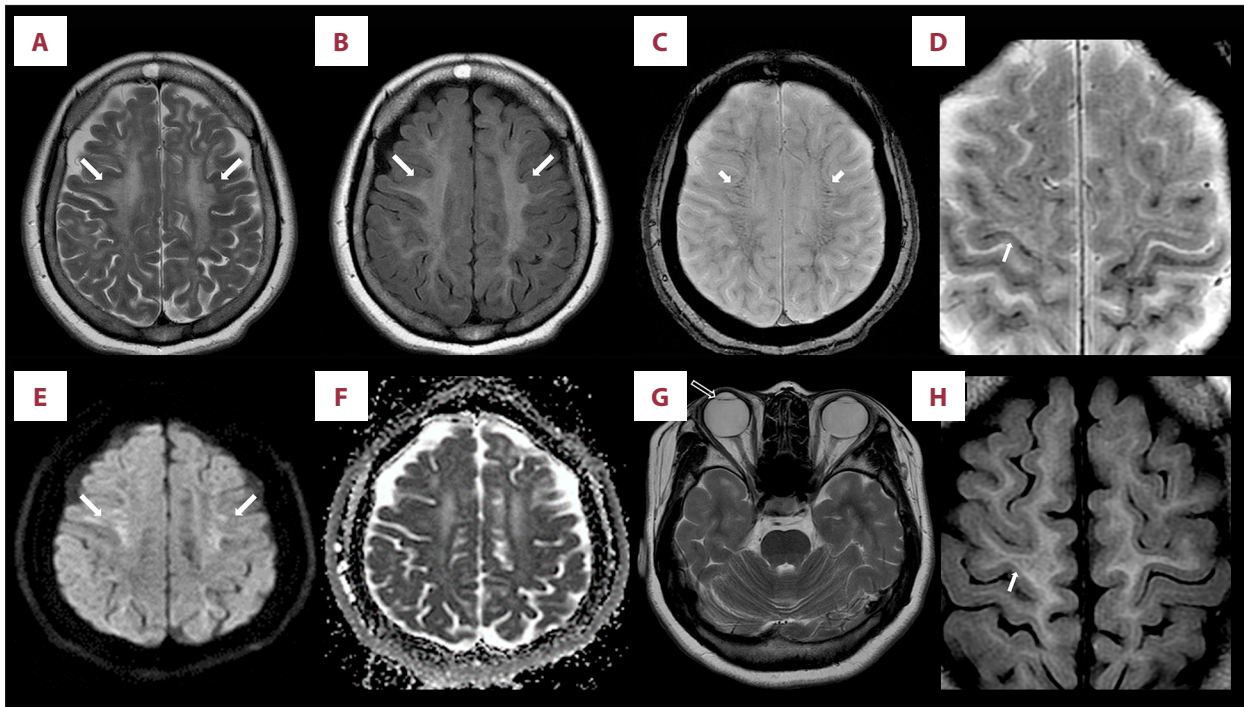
A 29-year-old female patient with VWMD. (A, B) Axial T2-weighted and fluid-attenuated inversion recovery (FLAIR) images shows diffuse and bilateral symmetrical hyperintensity in the cerebral white matter. (C) T2* gradient echo image shows a diffuse, linear, and symmetrical hypointensity in the affected white matter (short arrow). (D) Magnification of an axial GRE T2*-WI apparently reveals diffuse linear juxtacortical white matter hypointensities. (E, F) Diffusion-weighted image reveals diffuse hyperintensity without diffusion restriction on the apparent diffusion coefficient map. (G) Axial T2-WI scan reveals bilateral intraocular lens insertion for congenital cataract (blacked arrow). (H) Magnification of an axial FLAIR image shows relatively spared juxtacortical white matter in the cerebral hemisphere.
